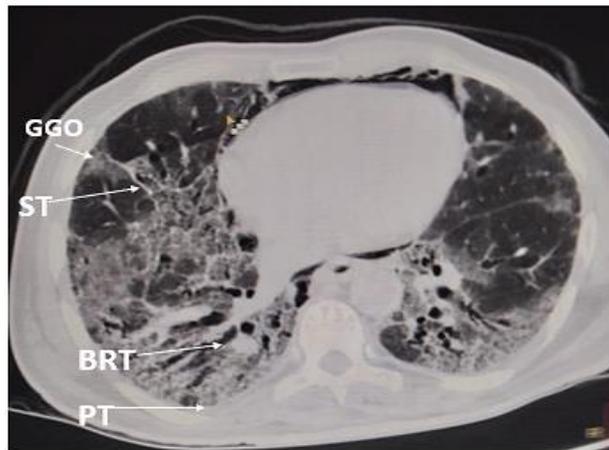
A chest CT scan showing GGO – ground glass opacity, ST – septal thickening, BRT – bronchiectasis changes, PT – Pleural thickening
